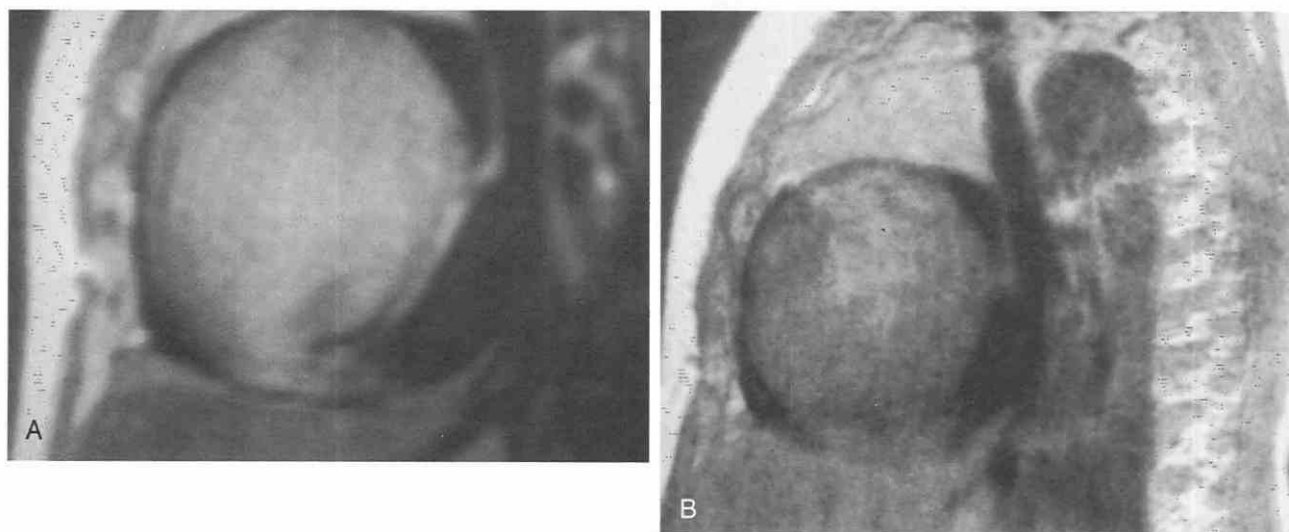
Cardiac fibroma in a 5-week-old infant who has had a murmur since birth. Sagittal cross-sectional echocardiographic unenhanced T1-weighted (*A*) and T2-weighted (*B*) images show a large, well-circumscribed soft tissue mass arising from the free wall of the right ventricle. Intermediate signal of the mass is noted on both sequences.
